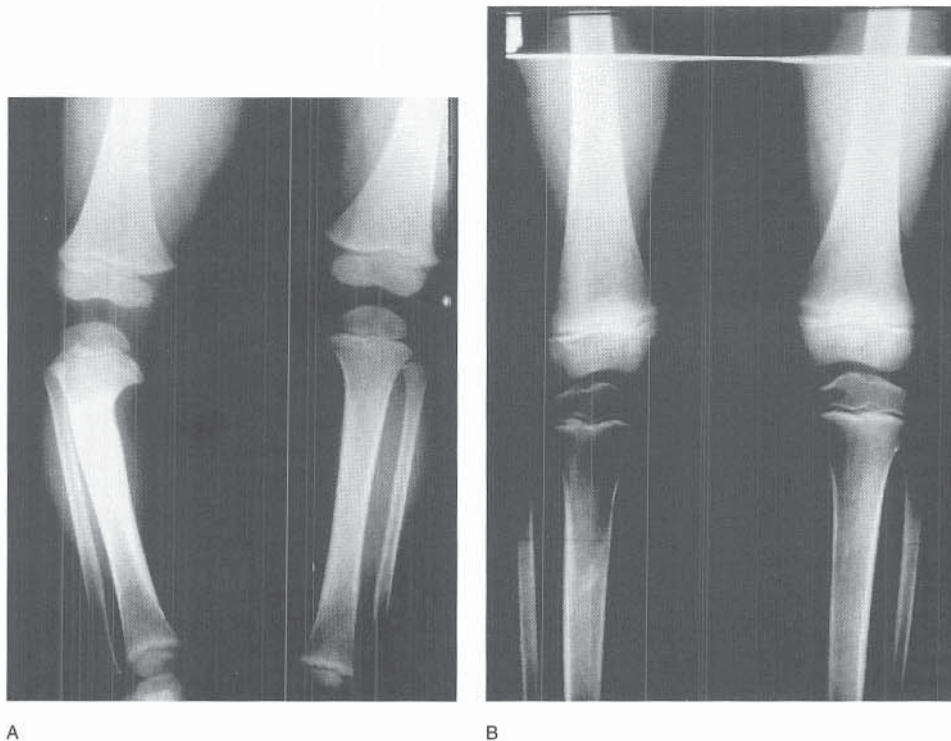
A, Radiographic appearance in a child age 1 year 10 months with focal fibrocartilaginous dysplasia and a possible Blount's lesion. The diagnosis of focal fibrocartilaginous dysplasia was not made at the time (1978). Bracing was instituted. B, Radiographic appearance at age 6 years 3 months. The tibia vara and all bony lesions have resolved.
